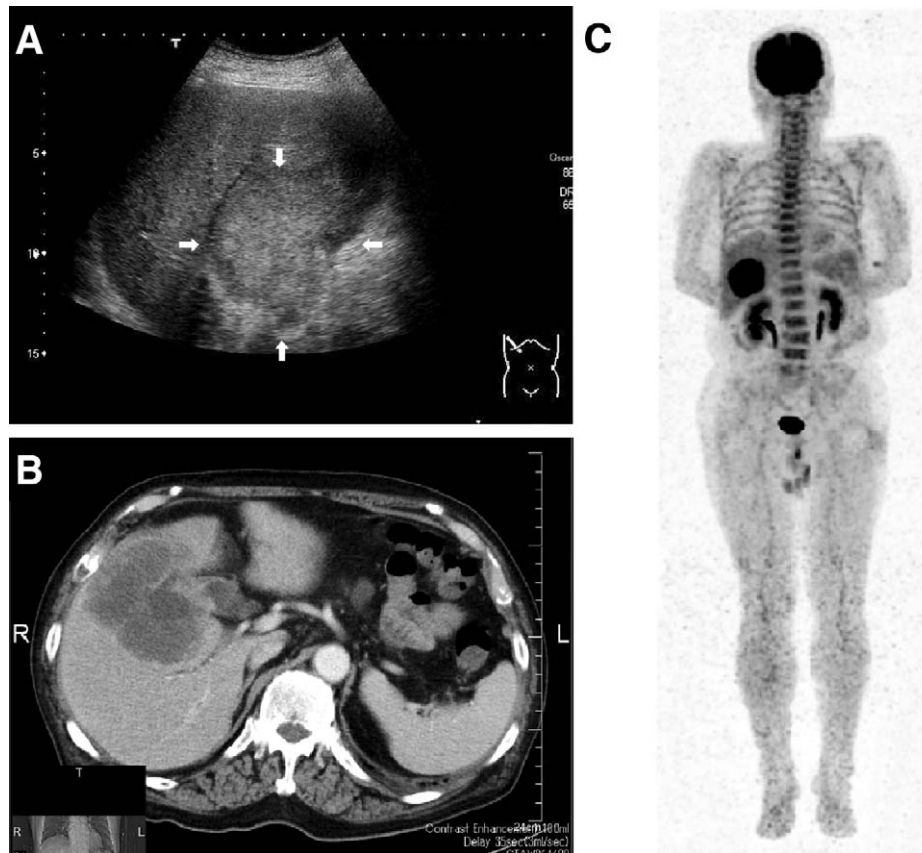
(A) Abdominal US showing an irregular mass with heterogenous echogenicity (arrows). (B) CT showing an irregular and peripherally enhanced mass. (C) FDG-PET showing markedly high uptake [the maximum standard uptake value (SUV_{max}) was 16.89] by the gallbladder tumor with diffuse uptake in the spine.
